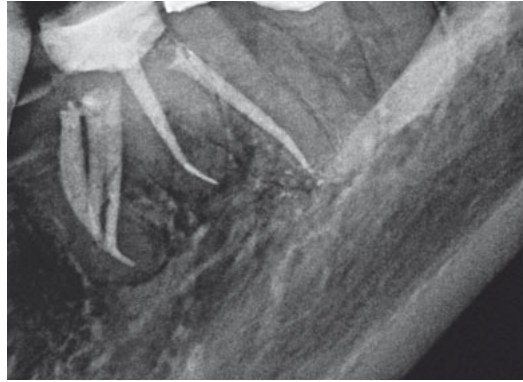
Control radiograph of the root canal filling in the angulated projection; the complexity of the root canal system can be identified much more easily.
